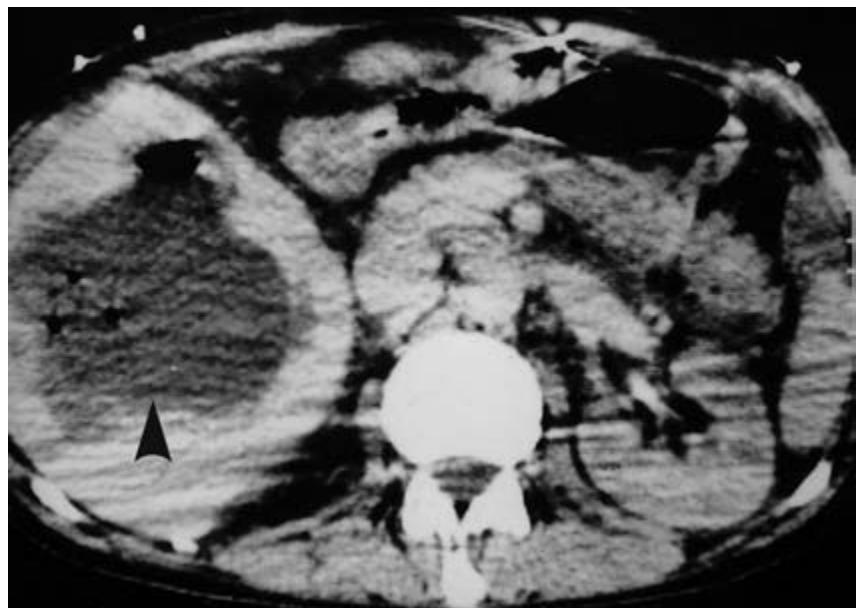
CT shows a large pyogenic abscess with thick shaggy walls in the inferior part of the right lobe of the liver (arrowhead). The abscess contains gas.
